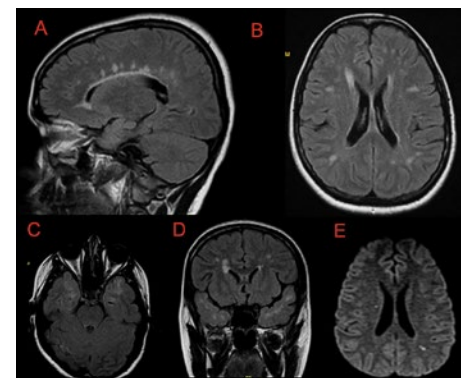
Magnetic resonance imaging (MRI) FLAIR sequence sagittal (A), axial (B, C) and coronal (D) cuts demonstrating periventricular and deep white matter hyperintensities of frontal, parietal and temporal lobes. MRI axial diffusion-weighted image (E) shows restricted diffusion in the right corona radiata and left parietal lobe.
